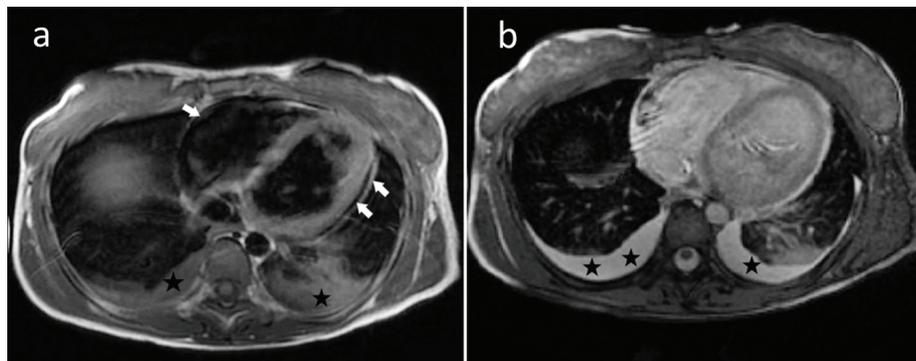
Cardiac magnetic resonance imaging showing trace pericardial effusion (Arrows) and bilateral pleural effusion (Stars).
